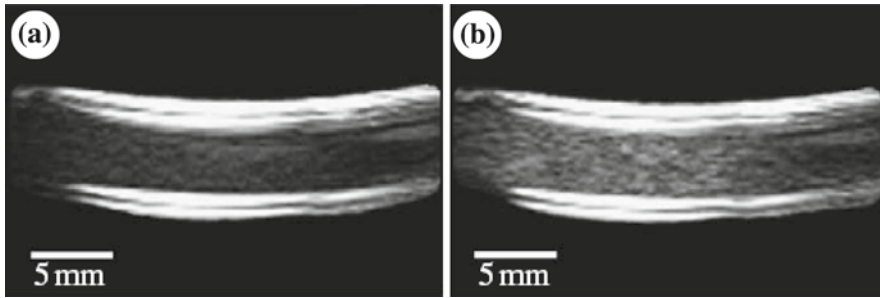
Ultrasonic images of blood flow in a vessel a before and b after microthrombi formation. Reproduced from [16]
